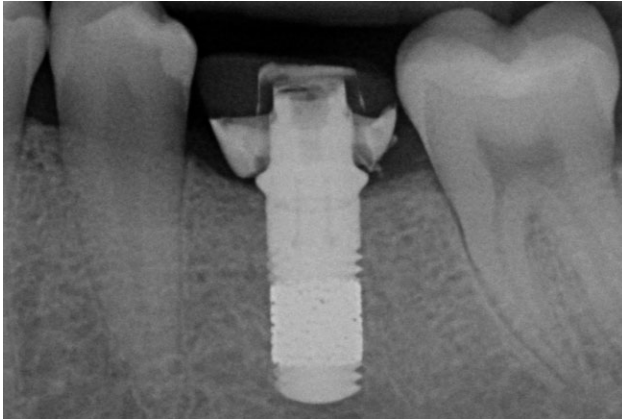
Postoperative (within 48 hours): radiograph of the provisional prosthesis in place.
